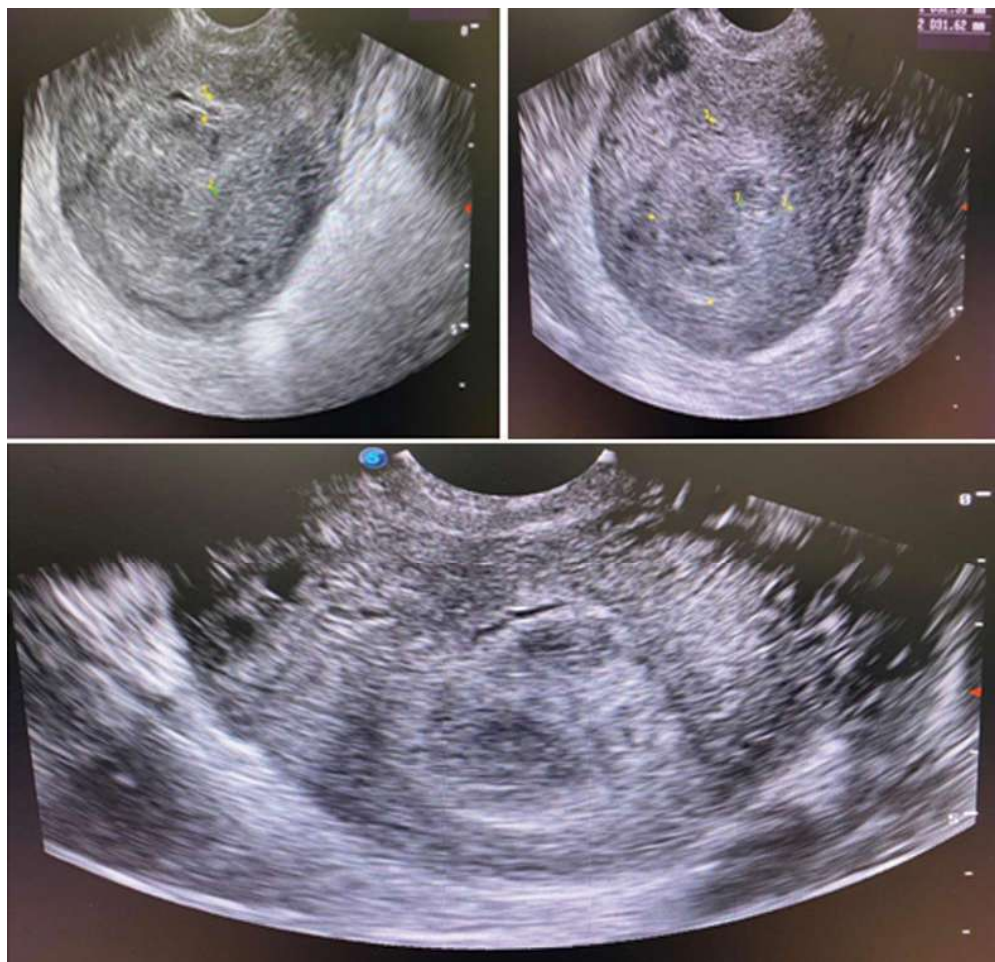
Ultrasound Images showing Ruptured Uterus.
